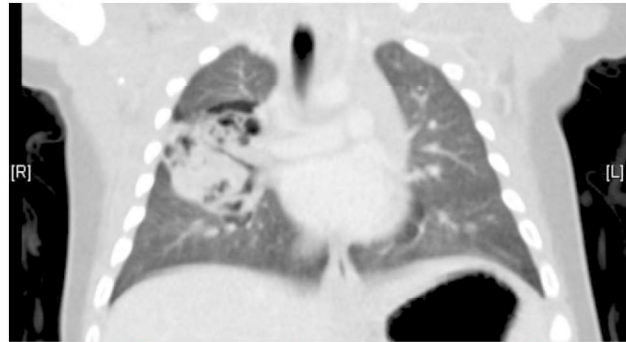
CT thorax shows a heterogeneous mass with internal small cystic components in right upper lobe, with probably involvement of right middle lobe. No definite arterial supply from the aorta is noted. Features suggest congenital pulmonary airway malformation (CPAM). Pathology of resected right lung later shows type III CPAM.
